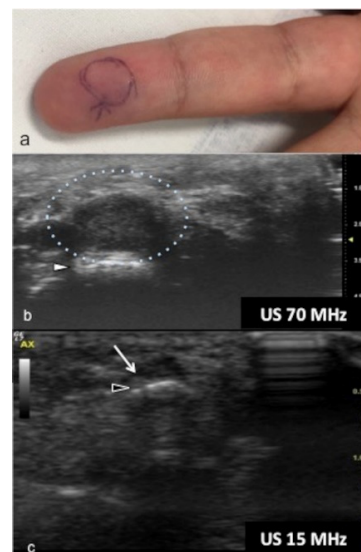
Glomus tumor. The location corresponds to the pulp of finger IV (a). The patient had the classical triad of symptoms: paroxysmal pain, pinpoint pain, and cold hypersensitivity, lasting for two years. In (b), UHFUS shows a well-delimited nodule in contact with the adjacent phalangeal bone (arrowhead), but no cortical deformity is present. No significant hyperemia on color Doppler was noticed. On CUS (c), the nodule was delineated only thanks to the help of the preliminary UHFUS exam.
